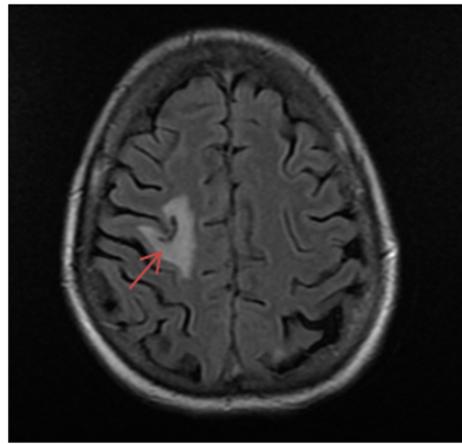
Fluid-attenuated inversion recovery (FLAIR) sequence of MRI brain, axial view, showed high signal intensity in the right frontal cortex.
